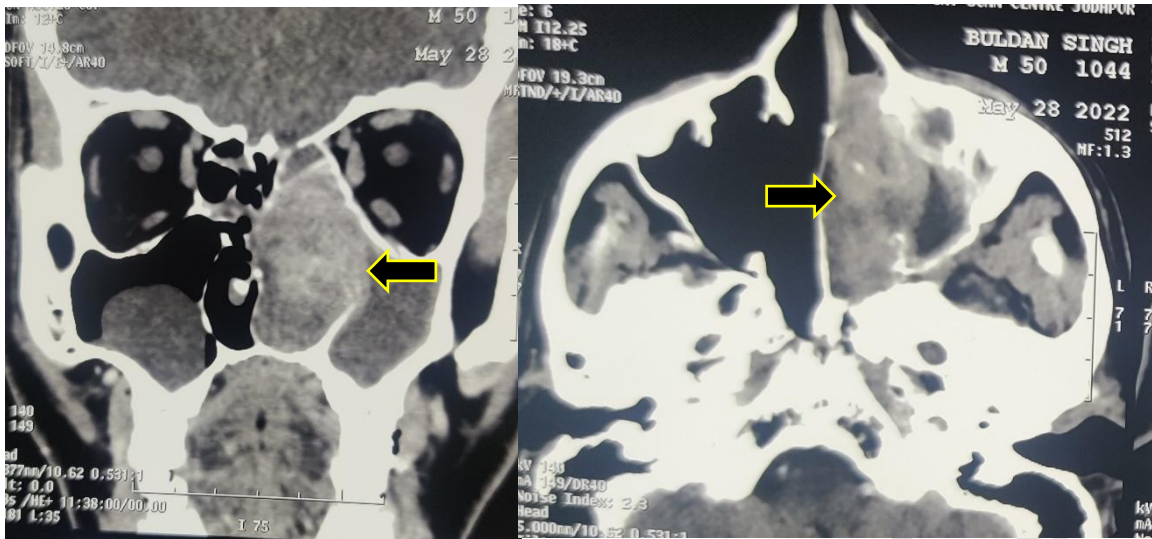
Axial + coronal computed tomography scan (soft tissue window) shows heterogeneously enhanced soft tissue mass occupying left side nasal cavity with retained section in left maxillary sinus.
